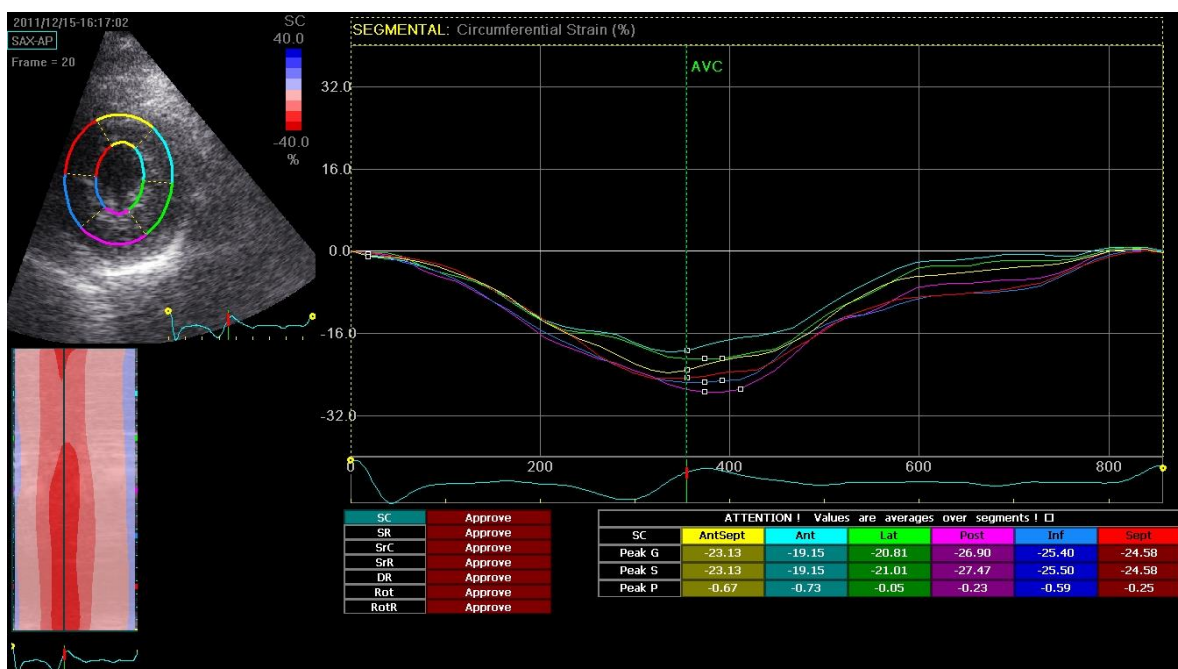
Strain curves and values using speckle tracking in the parasternal short axis for circumferential strain
